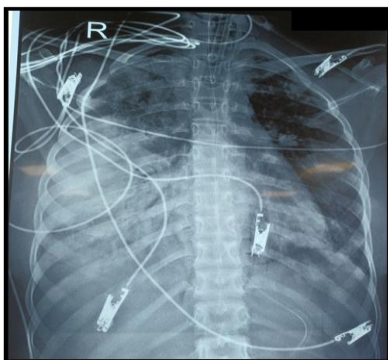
Chest X-ray showing marked consolidation in the right middle and lower lobes (1<sup>st</sup> Day)
